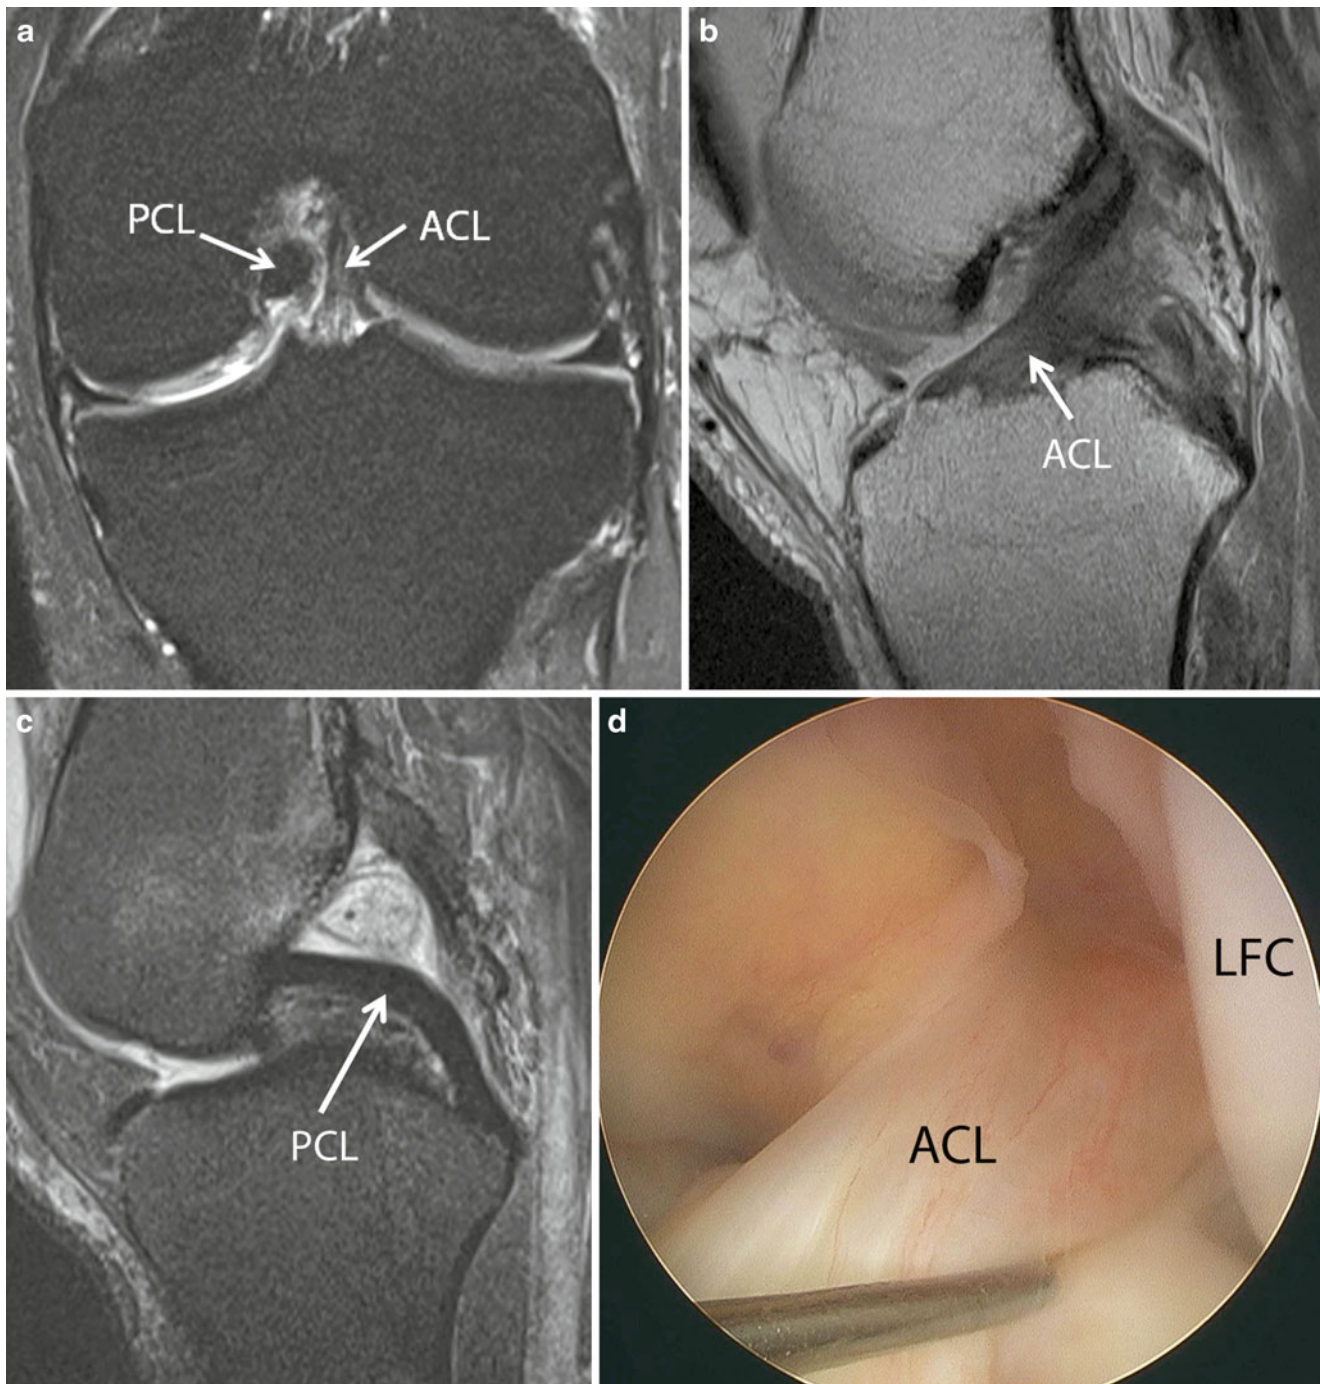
(a) Coronal T2-weighted MRI image showing the intercondylar notch with the ACL and PCL. (b) Sagittal T1-weighted image of the ACL with its normal striated appearance. (c) Sagittal T2-weighted
